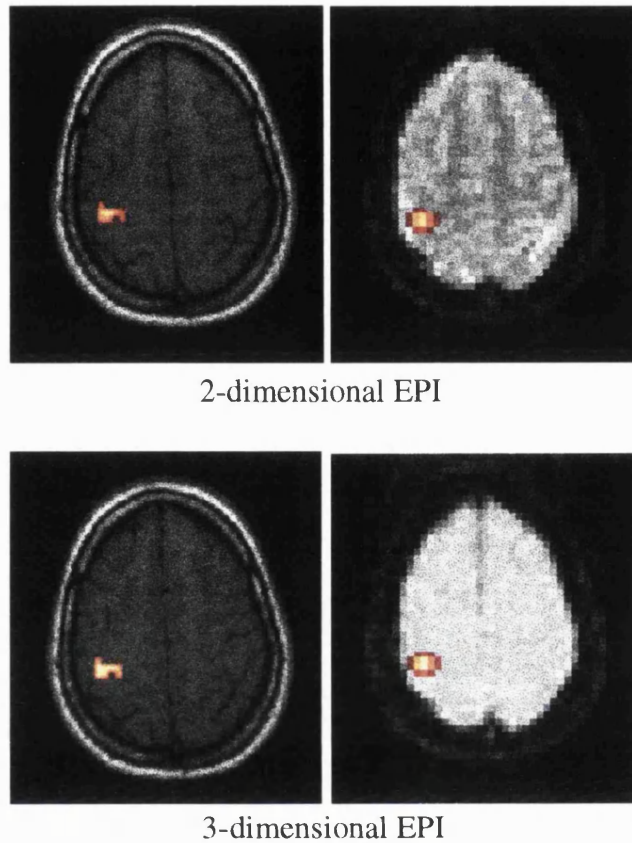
Example of contralateral sensorimotor cortex activation in one subject using 2-D and 3-D EPI sequences. Regions of activation are superimposed on to a T1-weighted anatomical slice (left) and a corresponding EPI base image (right). 2-D EPI produces images with a greater contrast than 3-D EPI.
